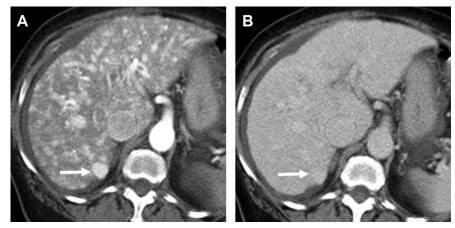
A 72-year-old woman with history of hereditary hemorrhagic telangiectasia (HHT). Axial hepatic arterial phase CT (A) shows an enhancing lesion in hepatic segment VII (*arrow*). The lesion remains mildly hyperdense compared with the background liver on 150-s delayed phase (B). Note numerous areas of arterioportal shunting as well as enlargement of hepatic arteries consistent with history of HHT. The segment VII lesion remained stable on follow-up imaging.
